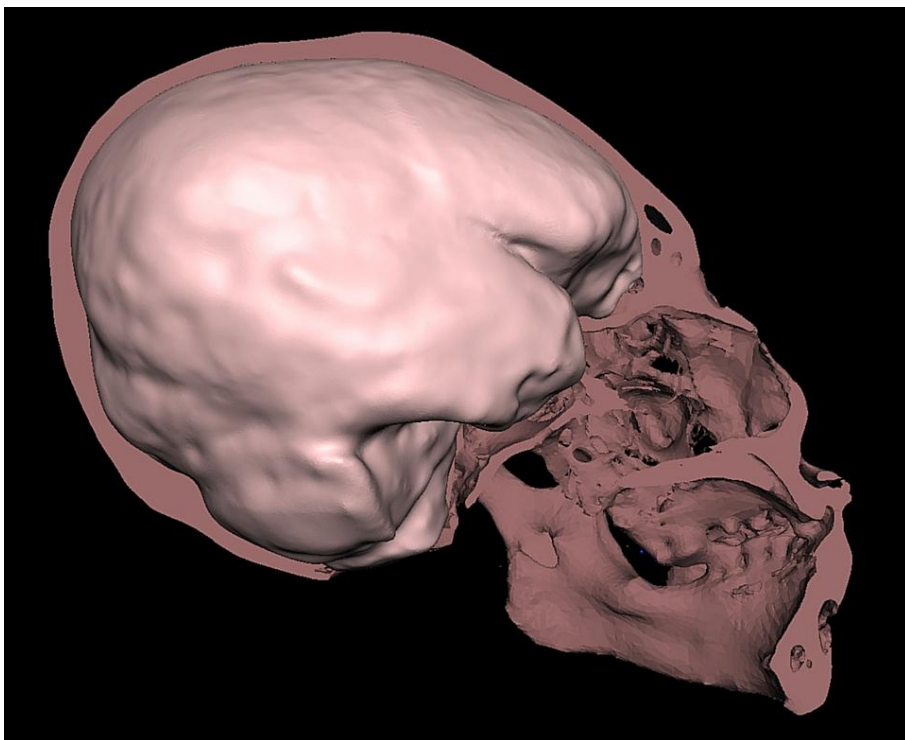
3D CT digital cranial endocast showing relatively small frontal lobes fitted into sagittal section of skull.
